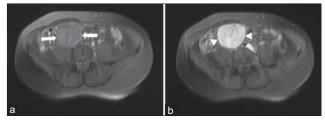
Axial fat-saturated T1-weighted magnetic resonance image revealed a mildly hyperintense lobulated mass (arrows in a) and heterogeneous high signal intensity after gadolinium administration (arrowheads in b)
